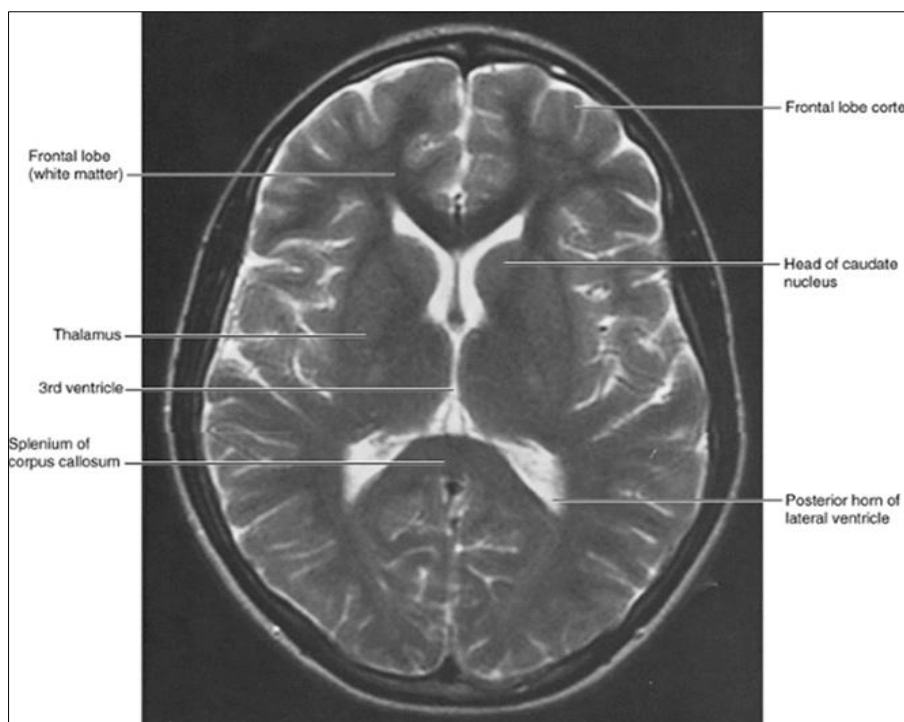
Cranial MRI- Courtesy; Keith Moore & Arthur Dalley
